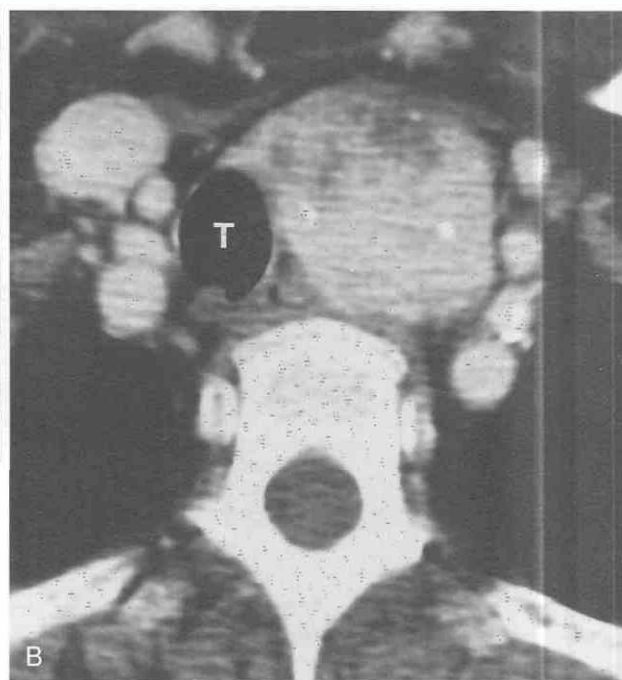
Thyroid goiter. A, CT shows heterogeneous superior mediastinal mass (arrowheads) with punctate calcification. Images at thoracic inlet (not shown) confirmed contiguity of mass with the left thyroid lobe, consistent with intrathoracic extension of goiter. B, Contrast-enhanced CT shows heterogeneous enhancement of mass. T, trachea.
